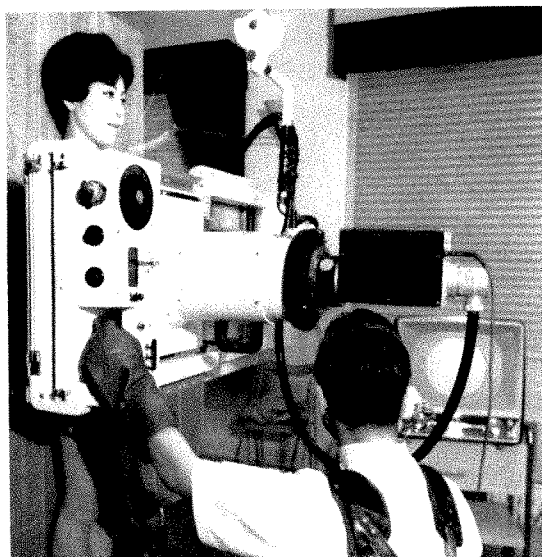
The examination room of the x-ray television system.
